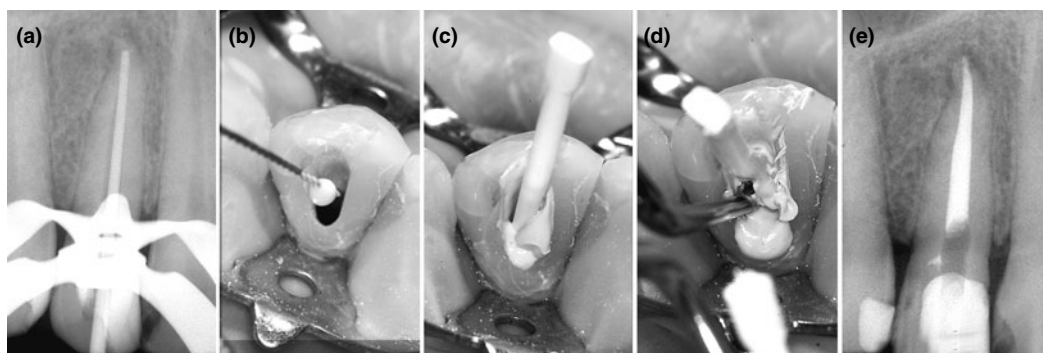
Clinical procedure for FP core carrier technique: (a) Fit of FP core is verified radiographically. (b) Sealer is placed in canal orifice with canal instrument. (c) FP core carrier is inserted to full working length. (d) Hot instrument is used to remove excess FP core and gutta-percha. (e) Post-operative radiograph.
